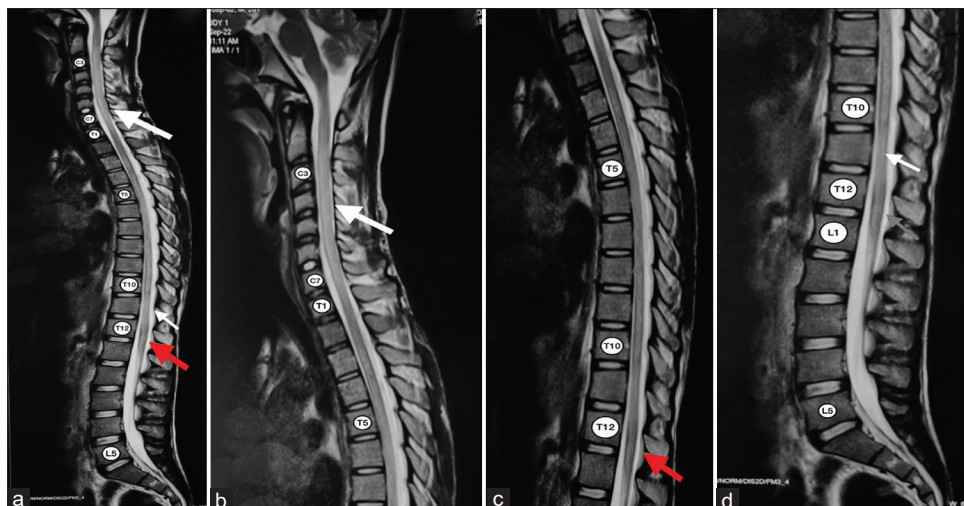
Contrast MRI Scans : (a) Shows subtle abnormal hyper-intense signals at multiple levels of the spine (white arrow) with fusiform dilation of spinal cord in sagittal T2 image (Red arrow); (b-d) Different Sections of the image in (a)
